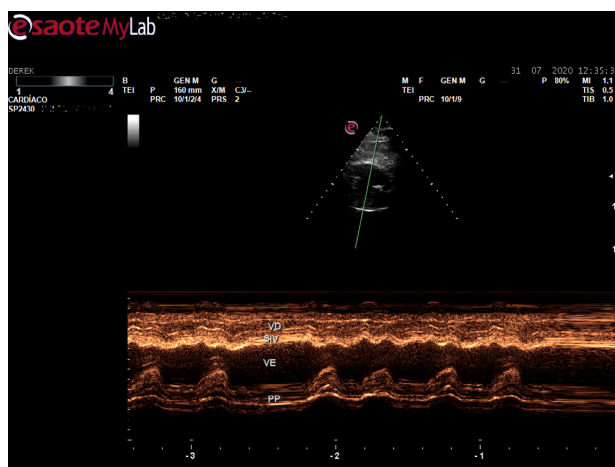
Left ventricular M-mode dimensional echocardiogram, right parasternal short axis view. VD: right ventricle; SIV: interventricular septum; VE: left ventricle cavity; PP: left ventricle posterior wall.
